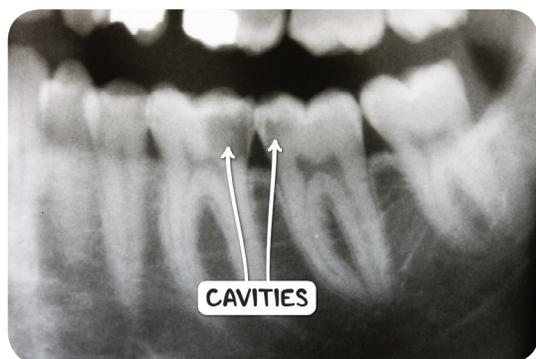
An orthopantomogram demonstrating dental cavities of the left mandibular second and third molar teeth.
